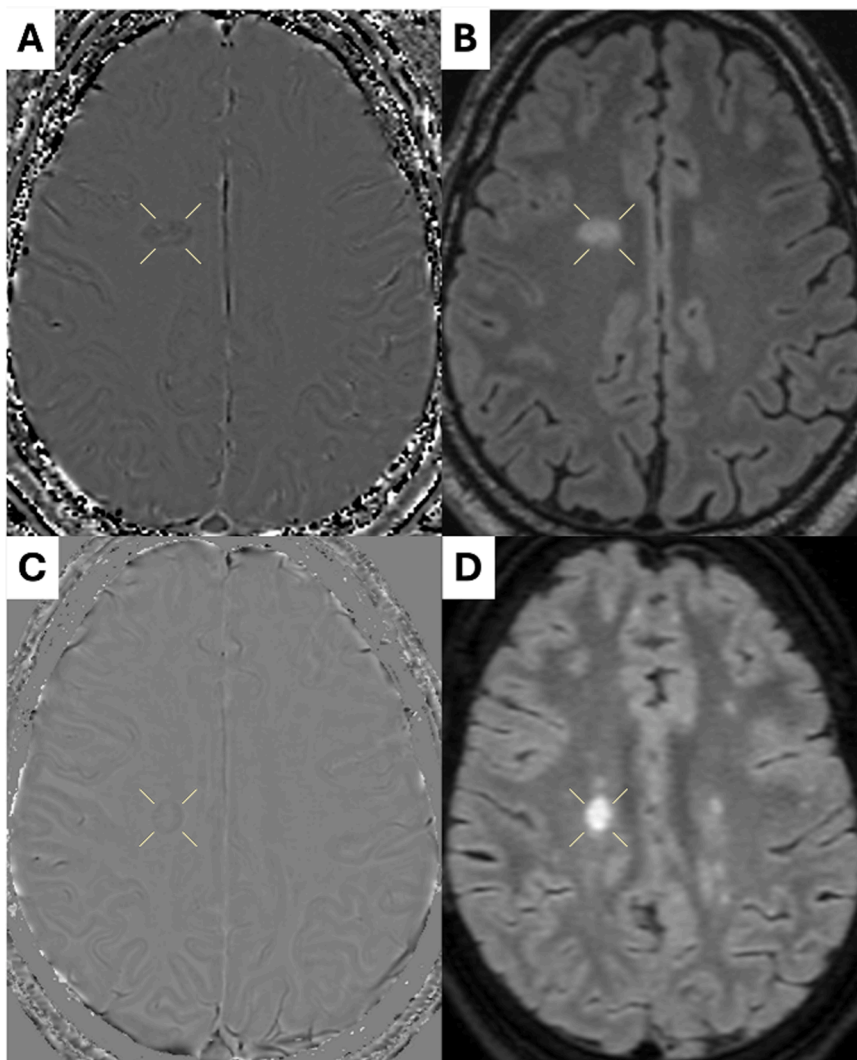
PRL findings from the two MRI scanners in the cohort. A & B: a PRL on filtered phase (A) and FLAIR (B) images from MRI scanner 1 (Siemens Magnetom Skyra Fit). C & D: a PRL on filtered phase (C) and FLAIR (D) images from MRI scanner 2 (GE Signa Premier).
